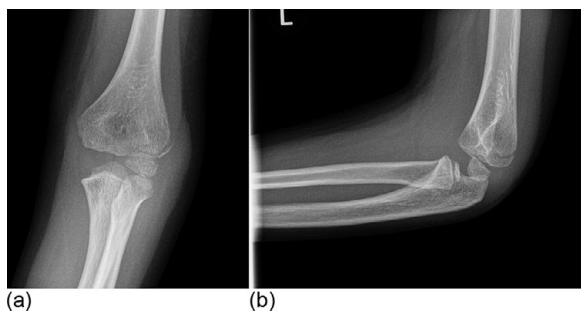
(a) Anteroposterior (AP) and (b) lateral radiographs left elbow
